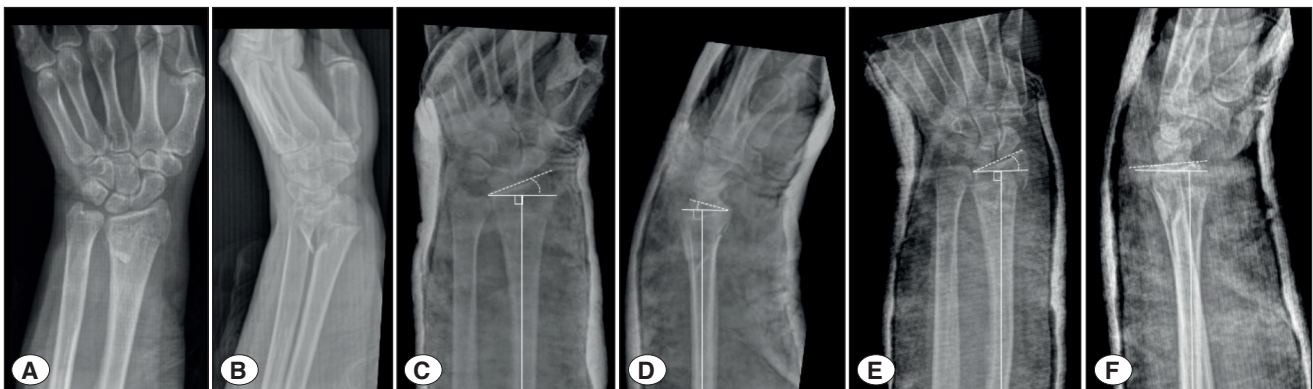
A) Anteroposterior (AP) and B) lateral radiographs of a 61-year-old female patient with AO type 23-A distal radius fracture. After closed reduction, C) AP radiograph showed 20° of radial inclination and D) lateral view showed 8° of volar tilt. At 2nd week follow-up, there was a reduction loss on E) AP and F) lateral views with 14° of radial inclination, 5° of dorsal angulation, and 4 mm of radial shortening.
